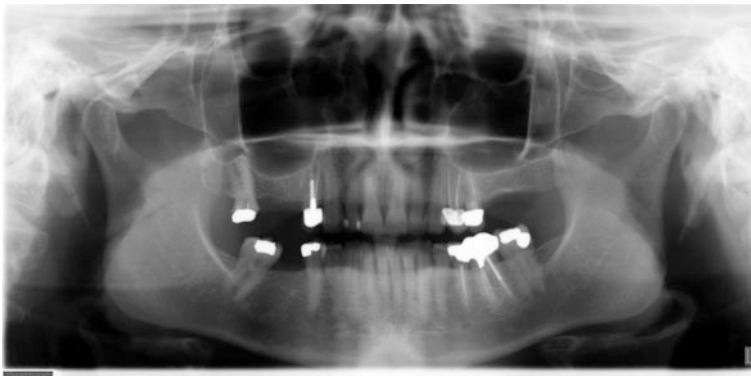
Panoramic radiograph is for initial screening of anatomic landmarks that may alter the placement of an implant. In treatment planning of a lower implant, location of the mandibular canal and mental foramen is critical. In an upper implant, the sinus walls should be noted
